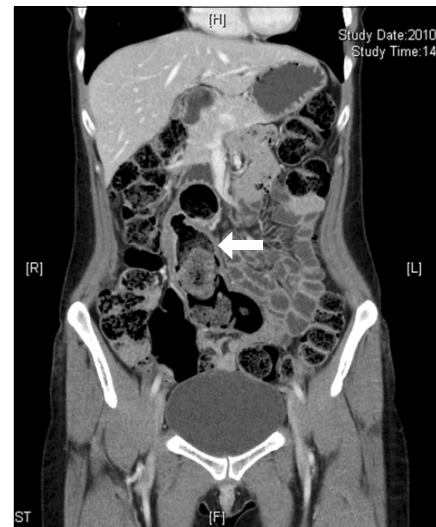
Coronal view abdominal computed tomography scan showing longitudinal section of colonic duplication (white arrow).
